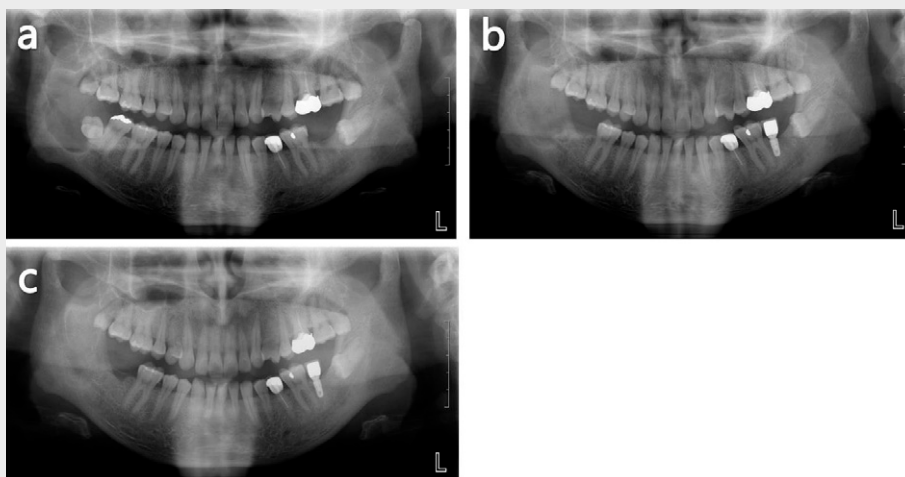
Panoramic X-rays of case 1.
